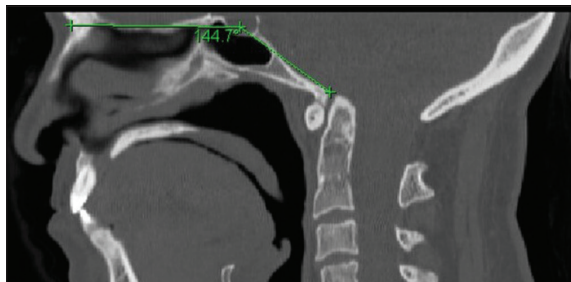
Preoperative lateral cervical spine radiograph demonstrating the angle of the nasion to the pituitary to the anterior margin of the foramen magnum. The angle of >143-degrees is suggestive of platybasia.
